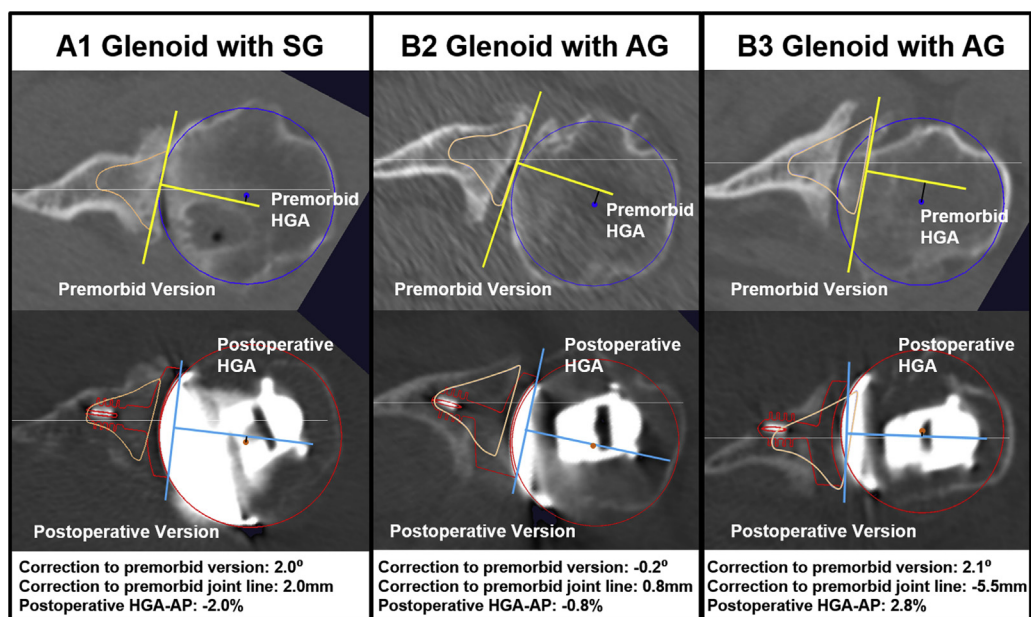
Comparison of type A1 glenoid treated with standard glenoid (SG) component, type B2 glenoid treated with posteriorly augmented glenoid (AG) component, and type B3 glenoid treated with AG component. The *top row* shows preoperative computed tomography scans with the glenoid vault model (*pink outline*) placed into the pathologic glenoid. Premorbid version, the premorbid medial-lateral joint line position, and premorbid humeral glenoid alignment (HGA-AP) are shown. The *bottom row* shows postoperative computed tomography scans with the position of the glenoid and humeral head components outlined in *red*. Glenoid component version, the medial-lateral joint line position, and HGA-AP are shown. The vault model remains in the same position on the postoperative computed tomography scans to measure preoperative-to-postoperative changes relative to premorbid anatomy. All 3 cases show good version correction relative to premorbid version, with a centered humeral head (HGA-AP) postoperatively. However, whereas the type A1 glenoid with an SG component and the type B2 glenoid with an AG component show restoration of the premorbid medial-lateral joint line position, the joint line of the type B3 glenoid with an AG component remains persistently medialized postoperatively (−5.5 mm relative to the premorbid joint line position).
